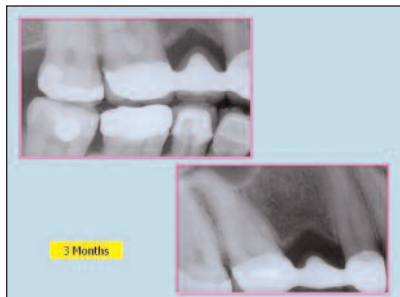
Radiographs at 3 months
